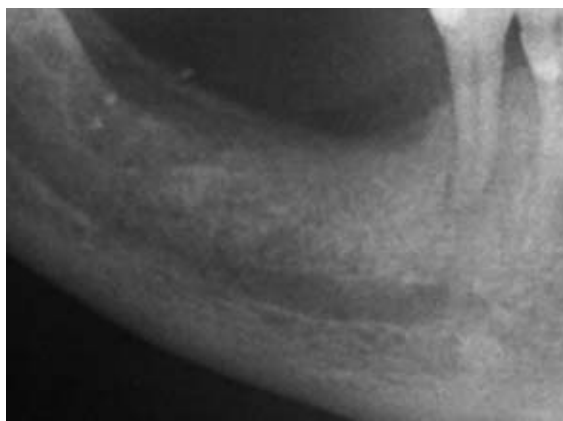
Preoperative radiograph of one of the patients included in the study.
